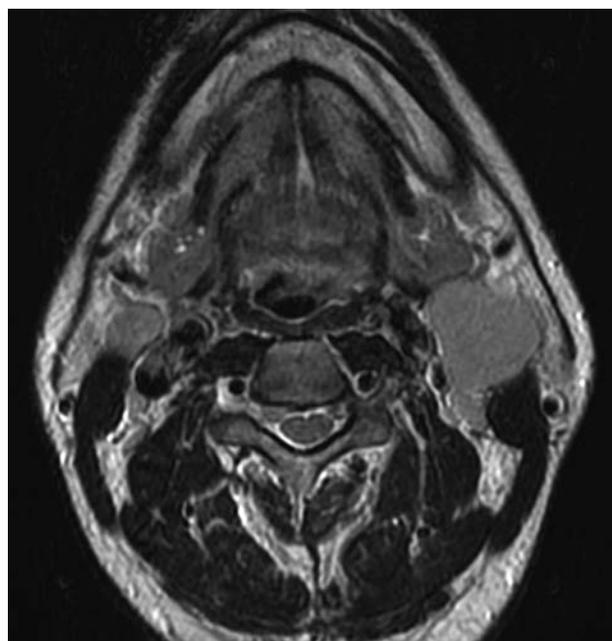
Axial T2-weighted MR image through the neck in a 45-year-old man presenting with neck masses. The enlarged solid left level 2A node measured 3.5 cm in maximal diameter with additional abnormal nodes seen on the right at 2A and bilaterally at levels 3 and 5A. No primary tumor was evident on clinical examination or on this MR imaging. In the absence of a primary tumor, it is difficult to determine which nodal table to use, though most unknown primary tumors are HPV/p16(+) OPSCC. If fine-needle aspiration of the node reveals HPV/p16(+), then an OPSCC primary would be assumed and this would be assigned T0N2. If pathology revealed HPV-negative, p16 negative, and ENB negative, then this would be assigned N2c and no primary site assigned. Fine-needle aspiration revealed this to be undifferentiated, nonkeratinizing carcinoma EBV+, with categories then assigned as T0N2 NPC.
